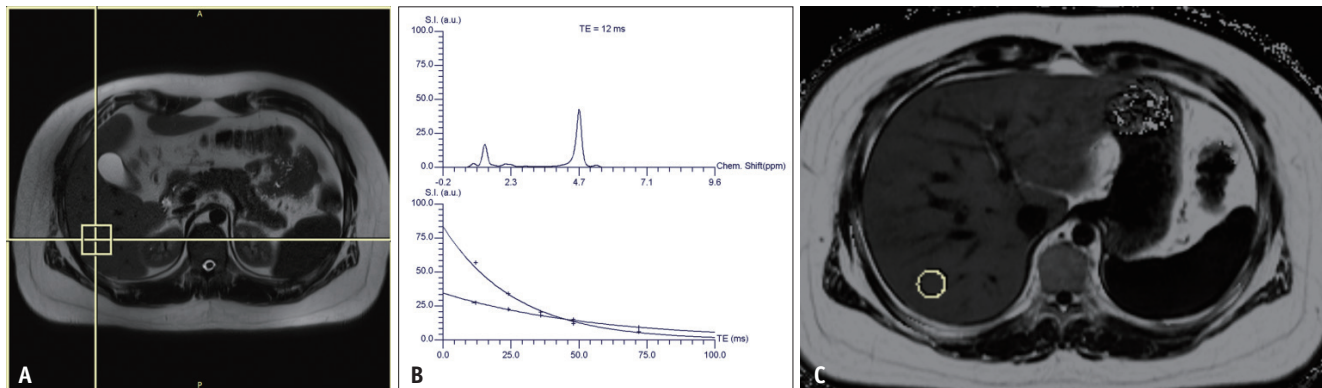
MRS (A, B) and MRI-proton density fat fraction (C) results of a patient with hepatic steatosis.
